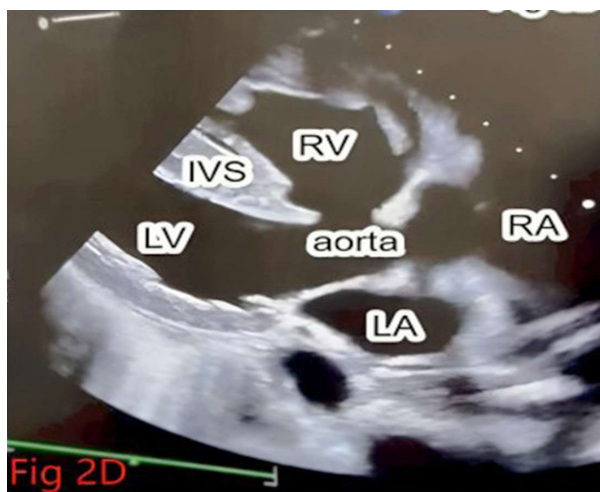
Shows an echocardiography image of the index patient showing an overriding aorta arising from both ventricles. RA - Right atrium, LA - Left atrium, RV - Right Ventricle, LV - Left ventricle, Ivs- interventricular septum
